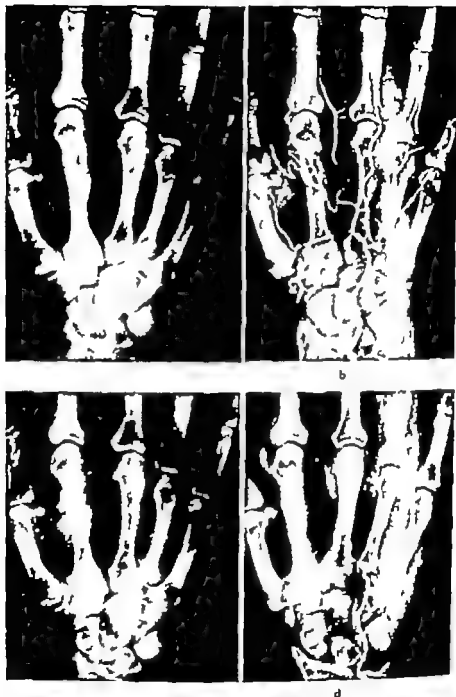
Case 1. a) Conventional radiography of the hand. Angiograph: 1) Arterial and 2) venous phase after intraarterially administered bradykinin. d) Same phase (b) about 10 minutes later.
